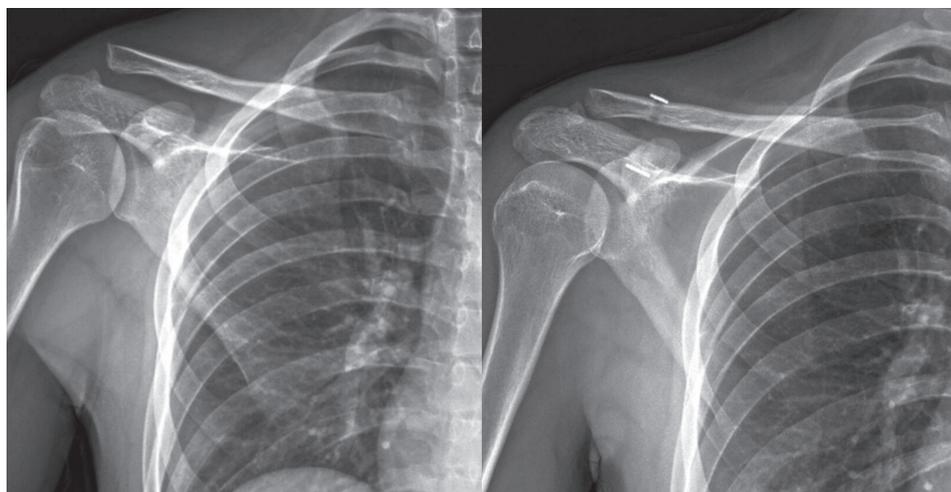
Pre-operative and post-operative X-rays of a 34-year-old male who presented with Rockwood type III acromioclavicular injury, treated with suture-button.
